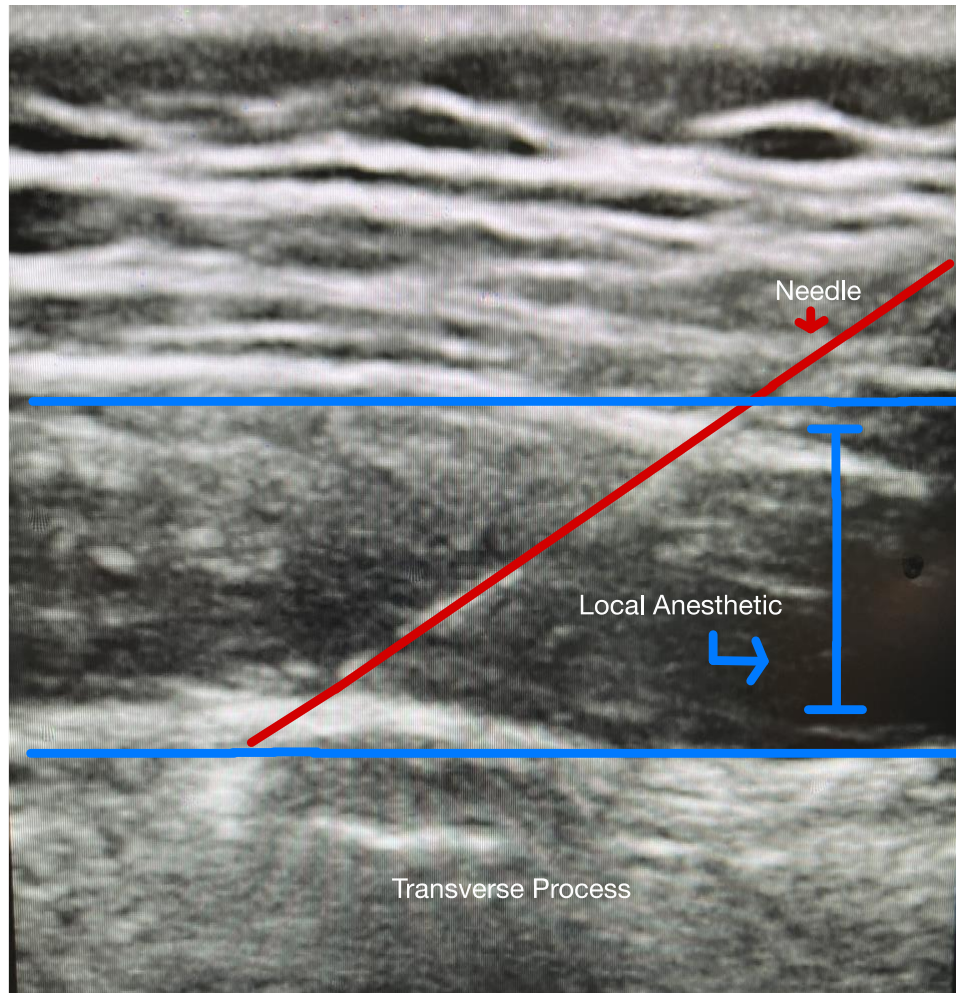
ultrasound-guided ESPB block.
